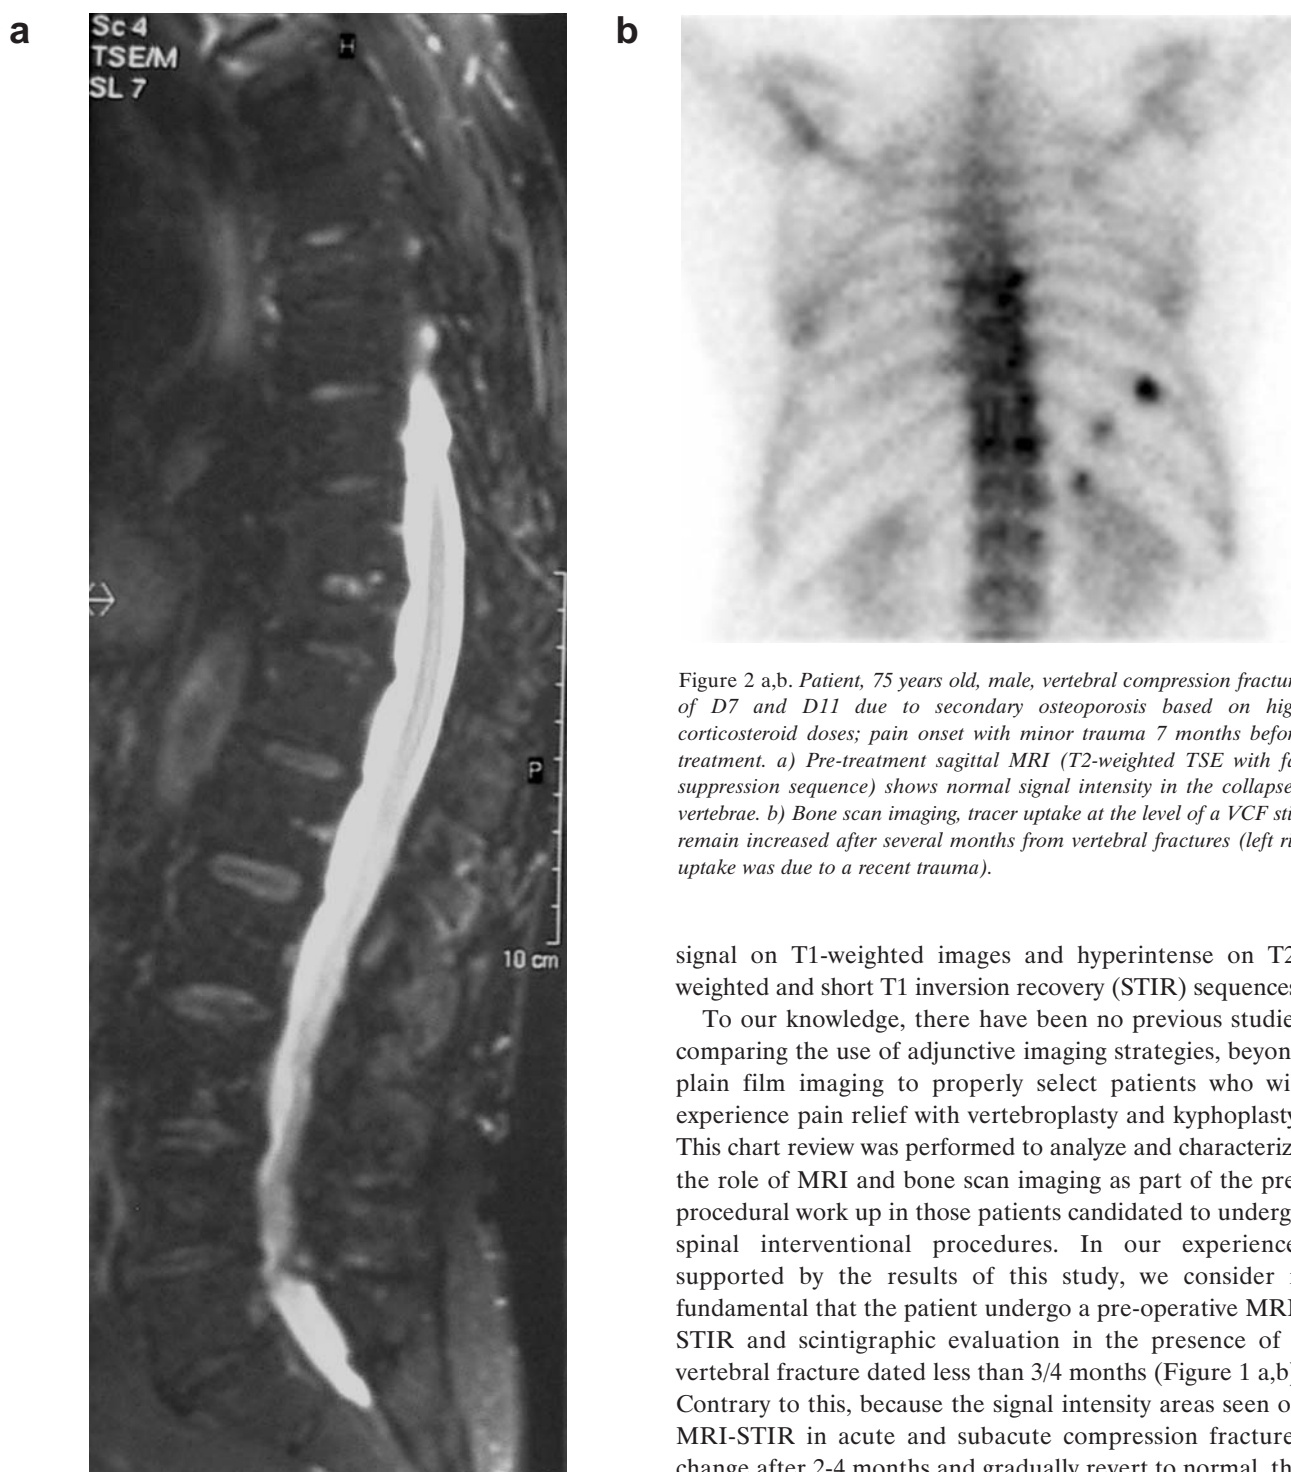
a,b. Patient, 75 years old, male, vertebral compression fracture of D7 and D11 due to secondary osteoporosis based on high corticosteroid doses; pain onset with minor trauma 7 months before treatment. a) Pre-treatment sagittal MRI (T2-weighted TSE with fat suppression sequence) shows normal signal intensity in the collapsed vertebrae. b) Bone scan imaging, tracer uptake at the level of a VCF still remain increased after several months from vertebral fractures (left rib uptake was due to a recent trauma).
